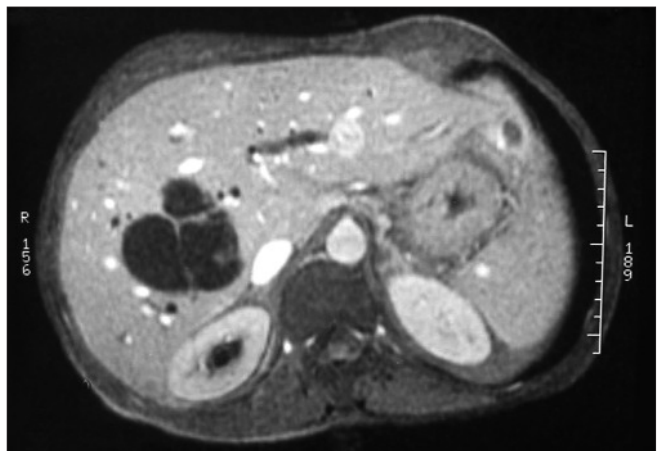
CT scan appearance of the intrahepatic cystic mass
